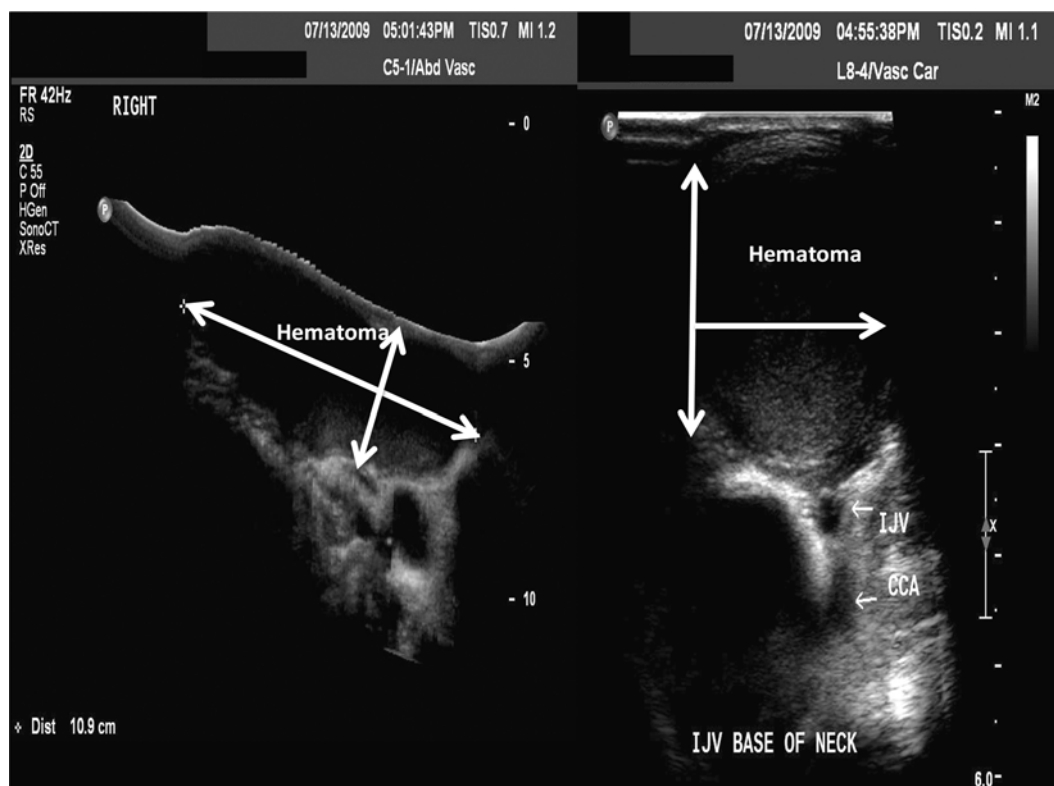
Duplex ultrasound showing a postoperative hematoma in two views (*arrow*) after line placement. *IJV* internal jugular vein, *CCA* common carotid artery
